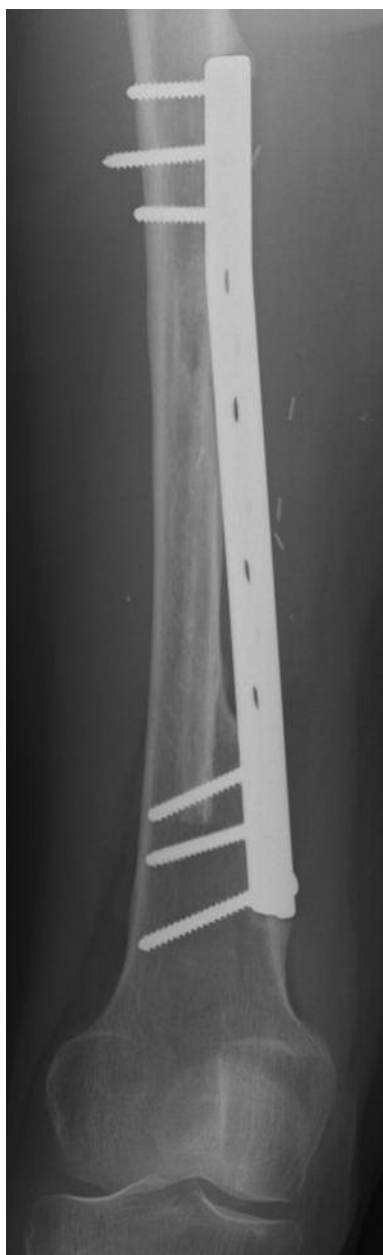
Same patient. Anteroposterior radiograph at 30 months follow-up showing very good integration of a fibular graft after screw-plate stabilisation.
